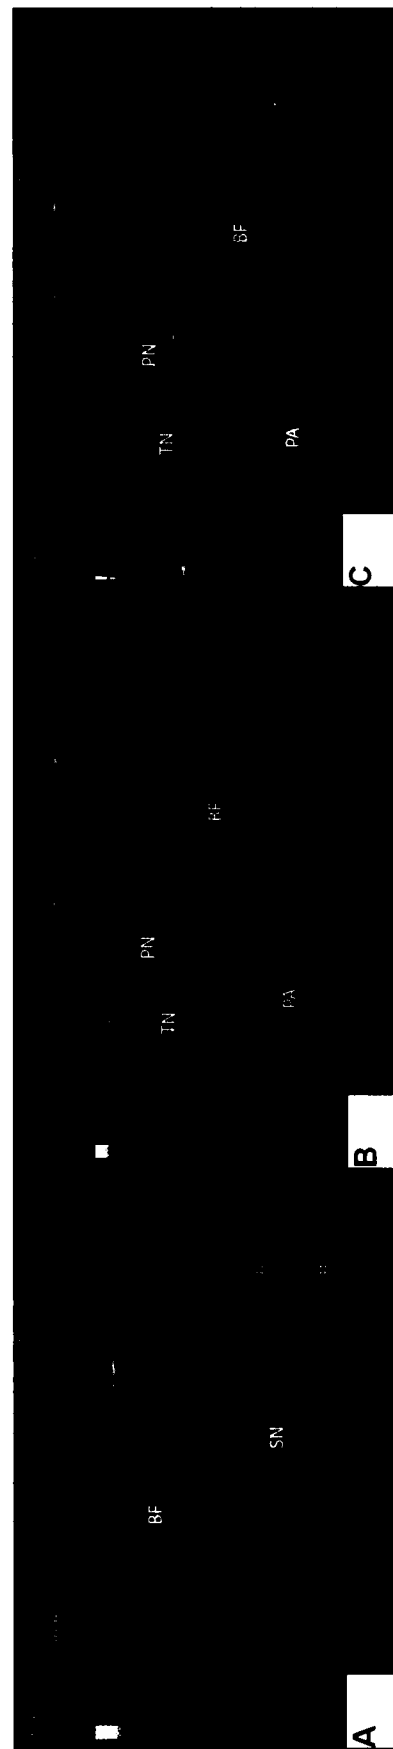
(A) Visualization of sciatic nerve before its division. (B) Cross-sectional imaging of the popliteal fossa showing the tibial nerve, peroneal nerve, popliteal artery, and biceps femoris. (C) Color flow Doppler demonstrates the blood flow inside the artery. BF, biceps femoris; PA, popliteal artery; PN, peroneal nerve; SN, sciatic nerve; TN, tibial nerve.
